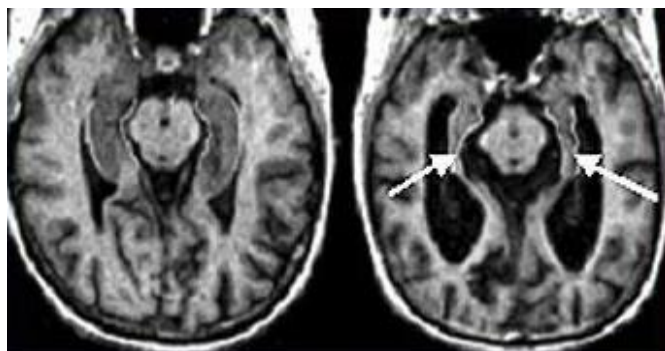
Brain view using MRI, left atrophy in Alzheimer's disease, right normal finding.
